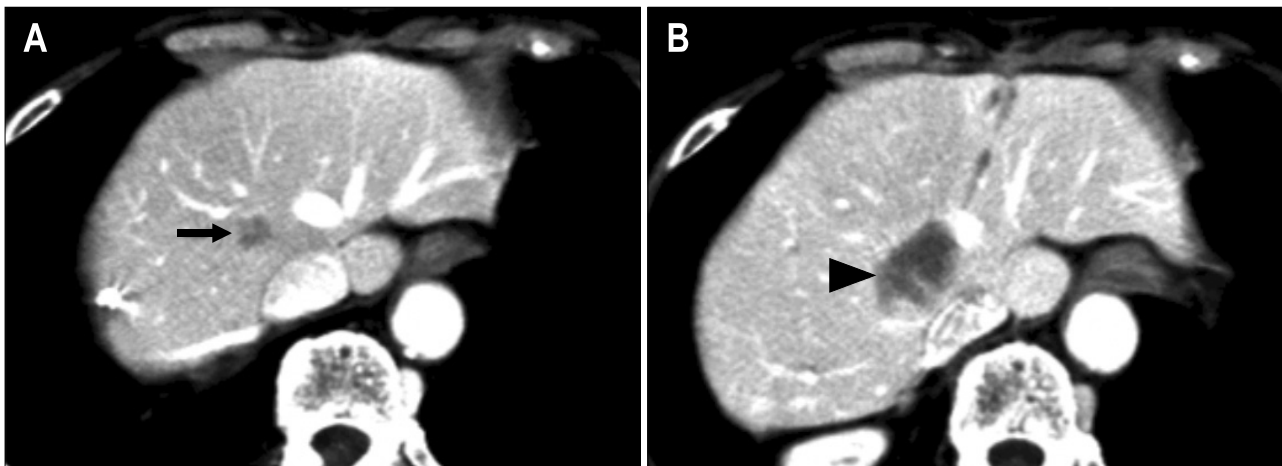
An 86-year-old man with a liver metastasis from the colon measuring 1.5 cm in diameter. (A) A portal-phase dynamic computed tomography (CT) scan showing a hypovascular tumor (arrow) in segment eight of the liver. (B) A portal-phase dynamic CT scan obtained 2 days after RFA showing that the tumor and surrounding area (arrowhead) are not enhanced. Thus, this tumor is considered to have been successfully ablated.
